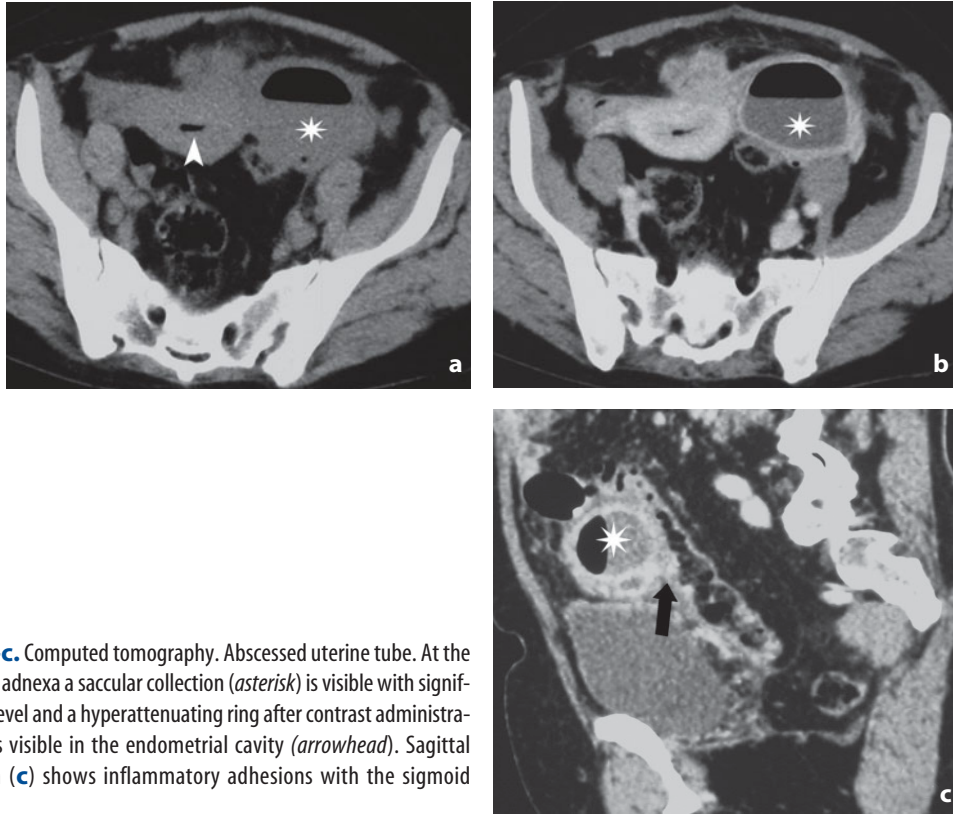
Computed tomography. Abscessed uterine tube. At the level of the left adnexa a saccular collection (*asterisk*) is visible with significant air-fluid level and a hyperattenuating ring after contrast administration (b). Air is visible in the endometrial cavity (*arrowhead*). Sagittal reconstruction (c) shows inflammatory adhesions with the sigmoid (*arrow*)
